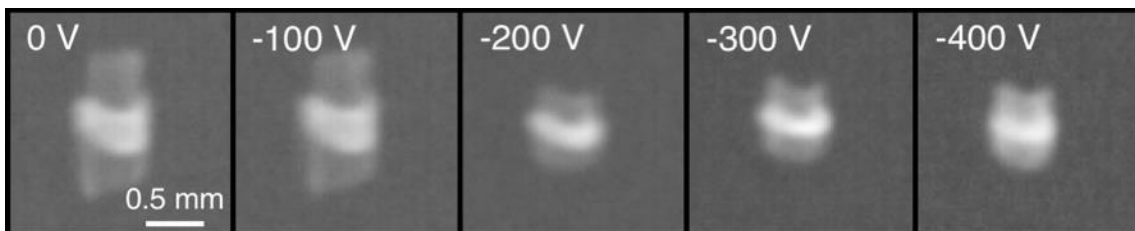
X-ray pinhole camera images of the x-ray focal spot as the grid bias (focus cup bias) is changed. 45 kV, 50 mA.
